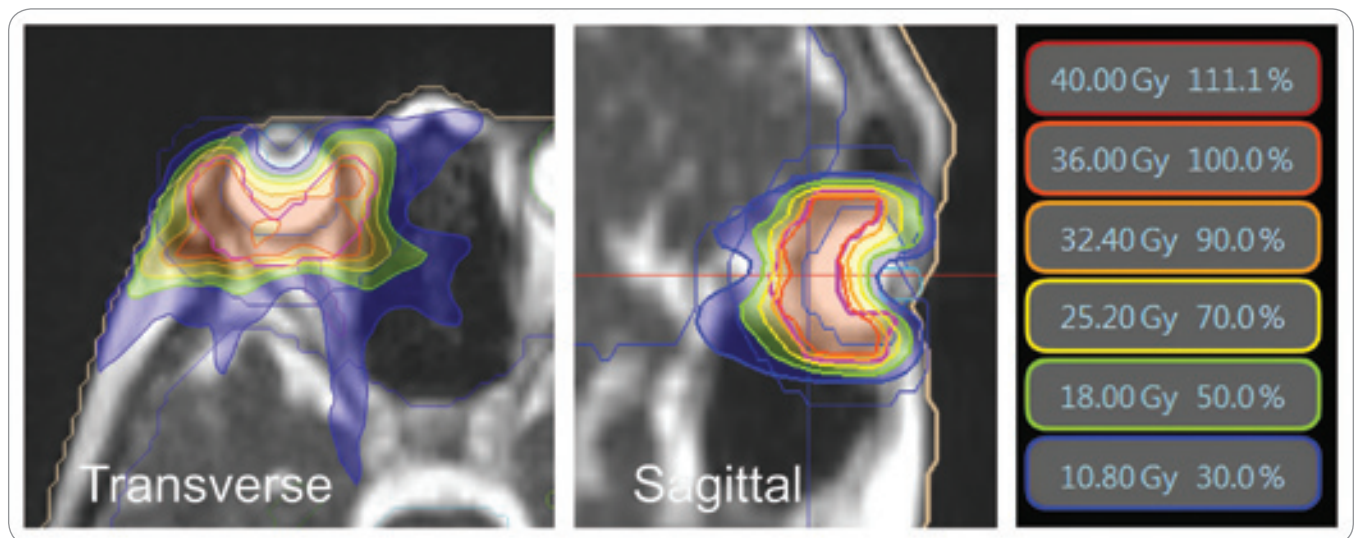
MRI-guided radiation therapy isodose lines with corresponding actual radiation dose.
